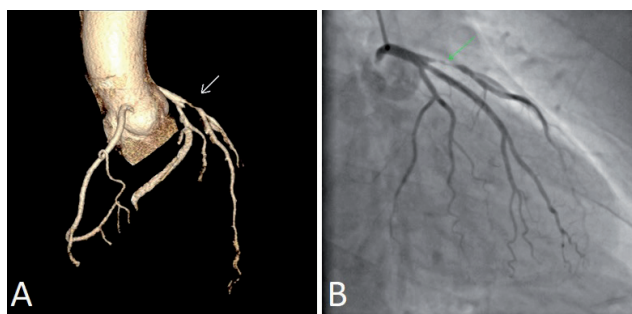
CT image (A) of representative patient with LDA 90% stenosis (arrow) subsequently indicated for PTCA (percutaneous transluminal coronary angioplasty) (B)
